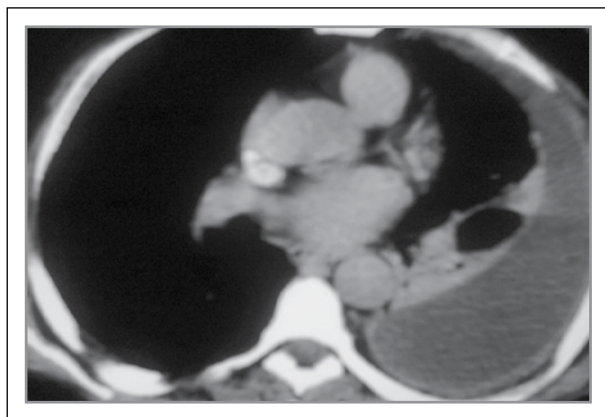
Chest CT with contrast showing TB empyema with entrapped lung
